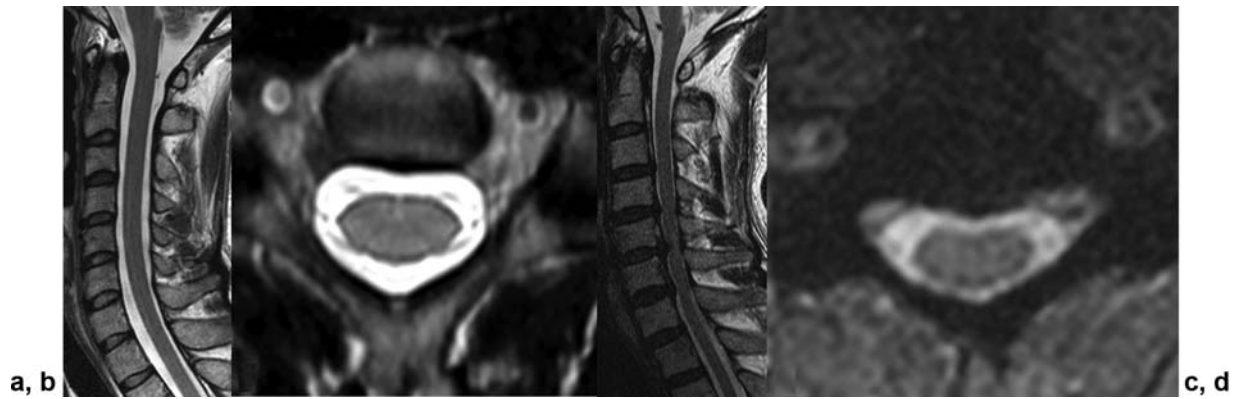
(a) T2-weighted sagittal and (b) axial images of patient with developmentally normal caliber cervical spine compared with (c) T2-weighted sagittal and (d) axial images of a patient with a developmentally small caliber cervical spinal canal. The patient with a developmentally small caliber cervical spinal canal has developed cord compression with only moderate disk bulging at C4–C5, C5–C6, and C6–C7.
